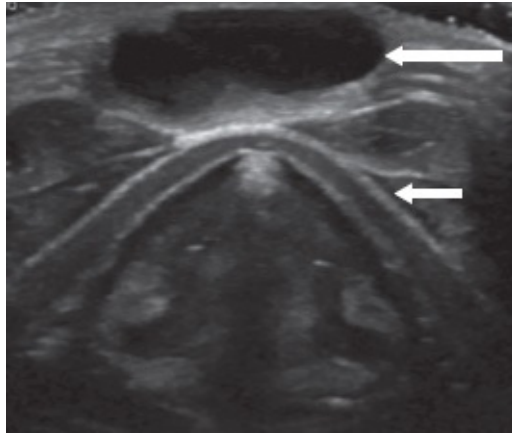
• Ultrasound scan of TGDC (*long arrow*) overlying thyroid cartilage (*short arrow*).
